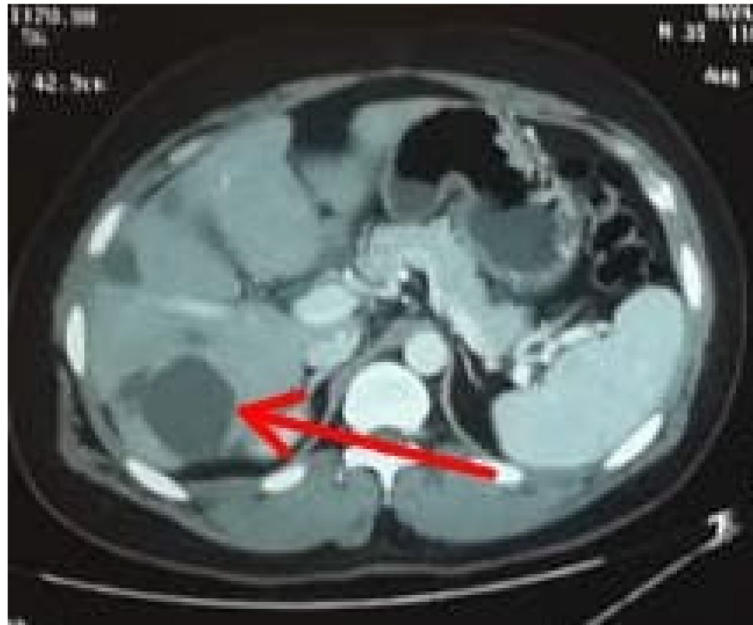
Axial CT showing hypodensity (red arrow) showing 5 cm × 8 cm on segment VI hydatid cyst
